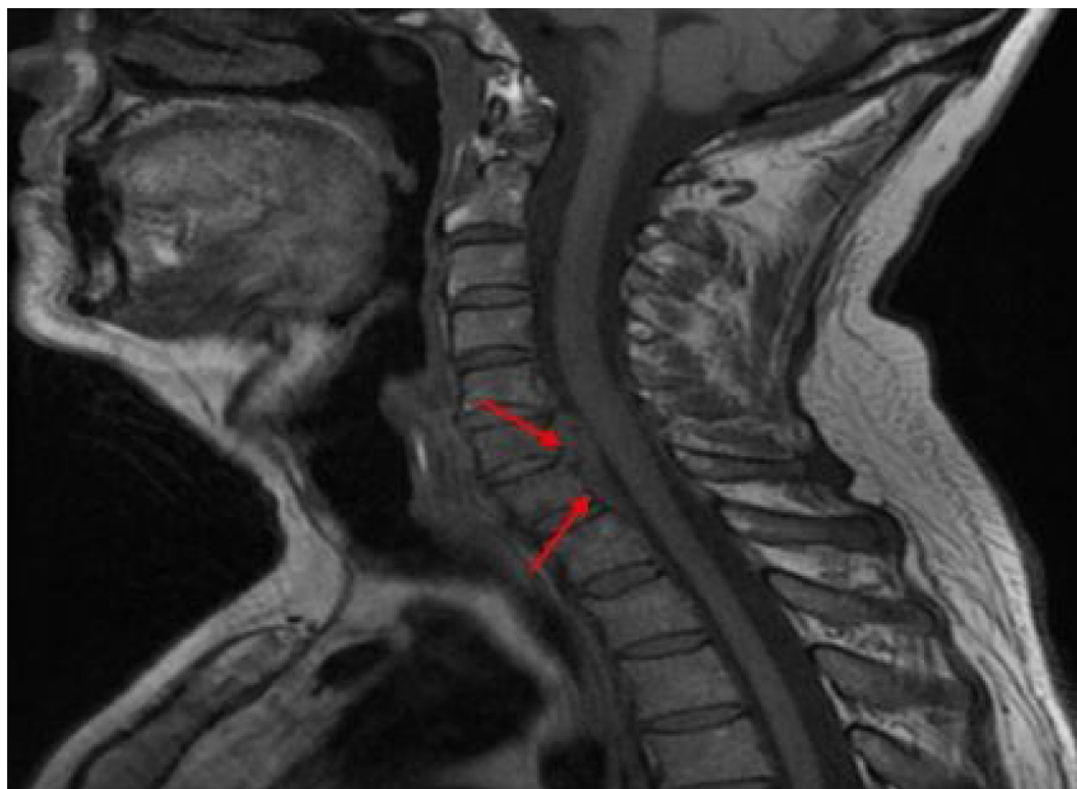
Sagittal cervical T1 weighted magnetic resonance imaging (MRI) showing epidural collection along the posterior aspect of C5–C7 vertebral bodies causing moderate spinal stenosis.
